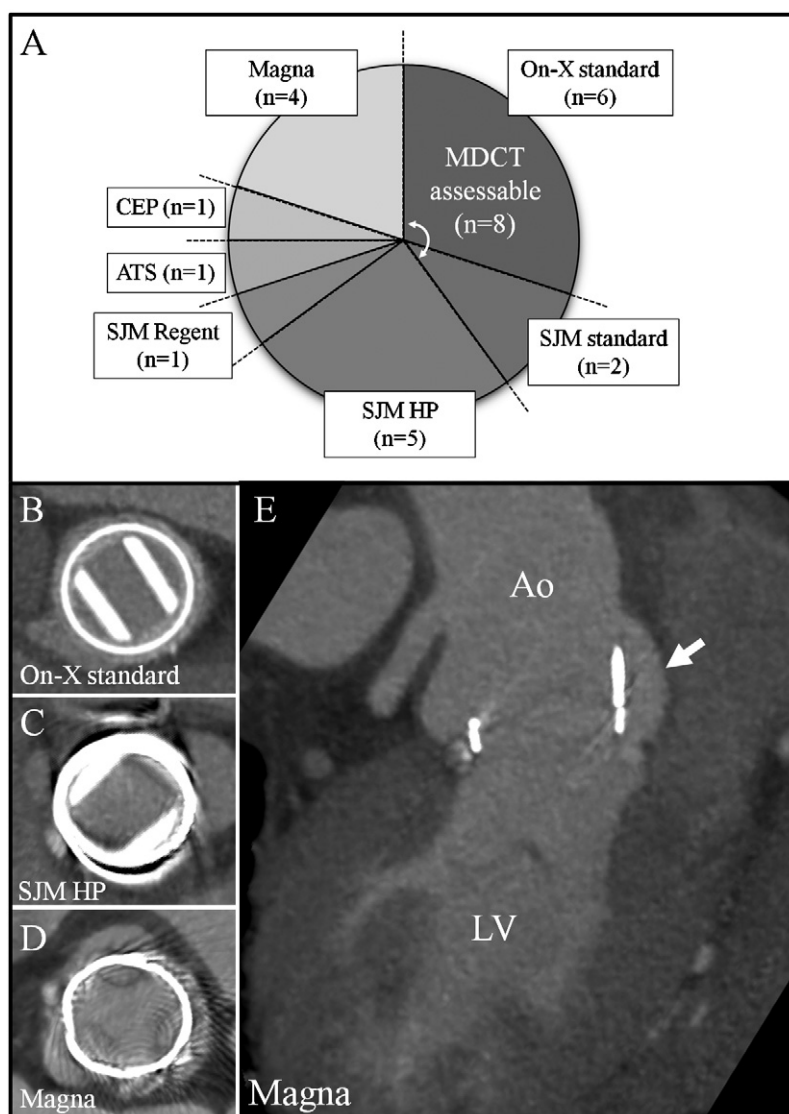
Relationship between valve type and presence of beam-hardening artifacts. Eight of twenty prosthetics could be evaluated for the presence of aortic paraprosthetic regurgitation (APR) by multi-detector computed tomography (MDCT) without beam-hardening artifacts (BHA) (A). On-X standard (B) or SJM standard valves were fully visualized without BHA. On the other hand, SJM HP (C), SJM Regent, and ATS valves showed significant artifacts which made the precise evaluation around prosthetics difficult. CEP or Magna valves (D) showed BHA around struts. However, possible APR was identified outside of the Magna valve (E, arrow). Ao, aorta; LV, left ventricle.
